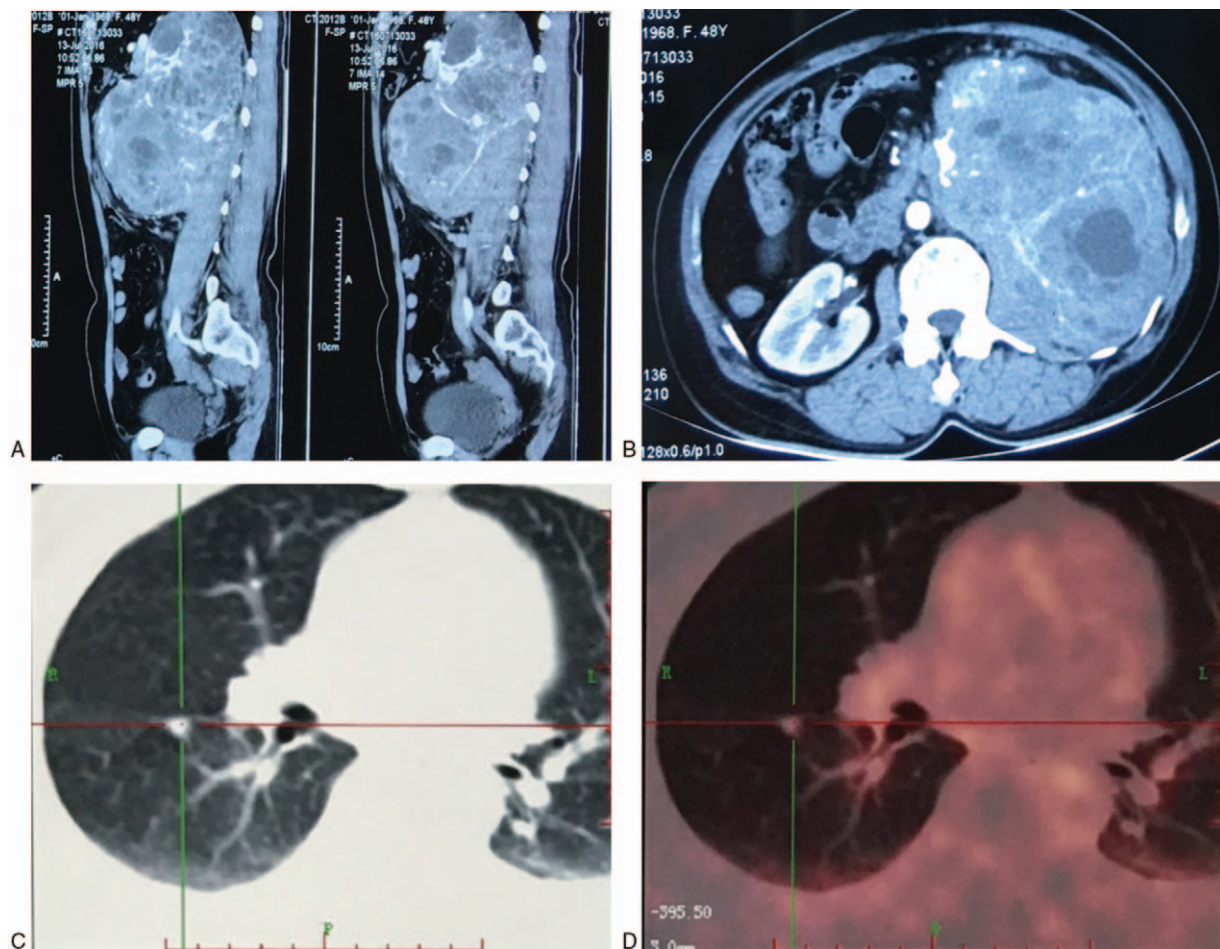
(A and B) Axial and sagittal computer tomography scans showing a large tumor with calcifications in the retroperitoneum. (C and D) Positron emission tomography–computed tomography scans showing focal activity in the lung, concern for metastatic disease (at the intersection).
